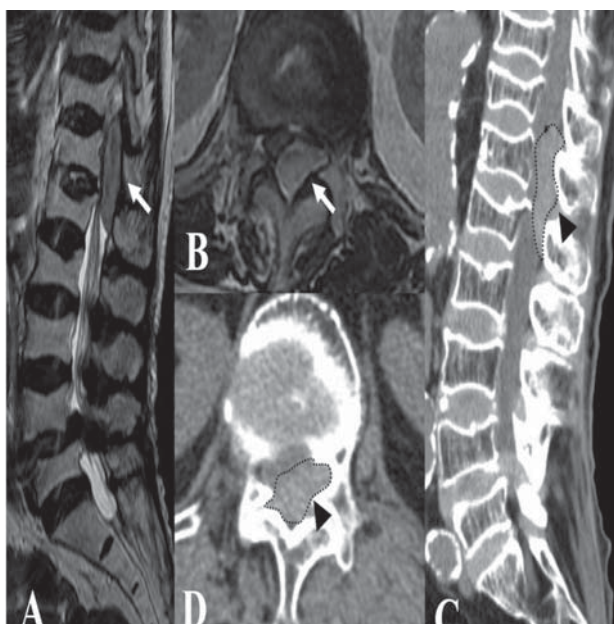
Thoracic MRI and CT showing SEDH from Th11 to L1; it has severely compressed the spinal cord
